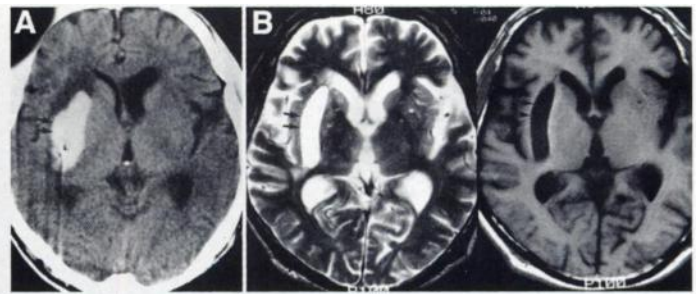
Diaschisis in patient with basal ganglia hematoma. (A) Initial CT shows intracranial hematoma in basal ganglia at hemorrhagic attack (arrows). (B) Follow-up MRI shows encephalomalacic change of affected area without cortical structural abnormality on T2- and T1-weighted images (arrows). (C) SPECT shows reduced regional cerebral blood flow in contralateral cerebellar hemisphere (small arrows), ipsilateral thalamus (closed arrow) and cerebral cortex (open arrow).
